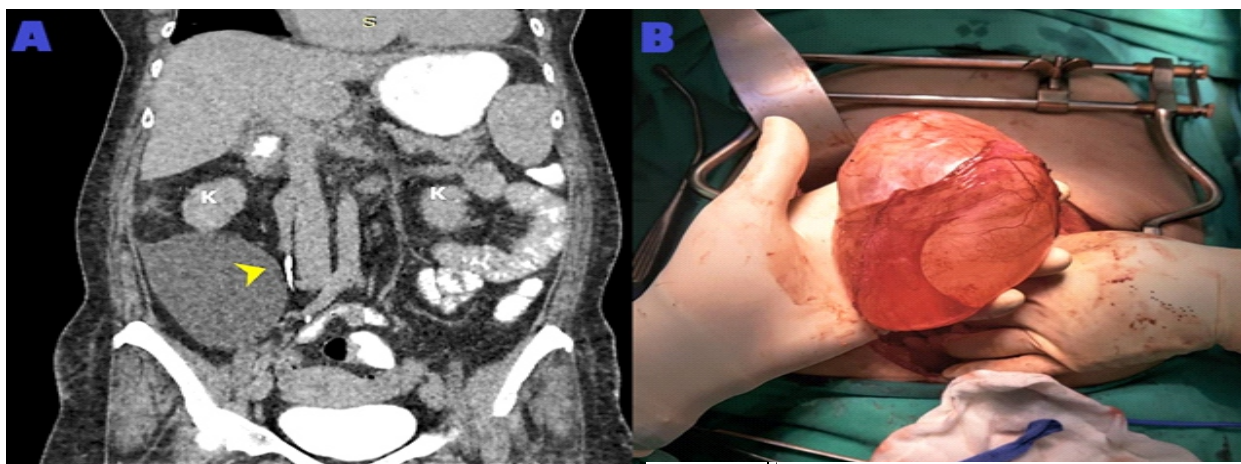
Contrast CT in delay phase revealed a large and well-defined retroperitoneal cystic mass with its medial side in close proximity to the right ureter (arrowed head). K: kidney
